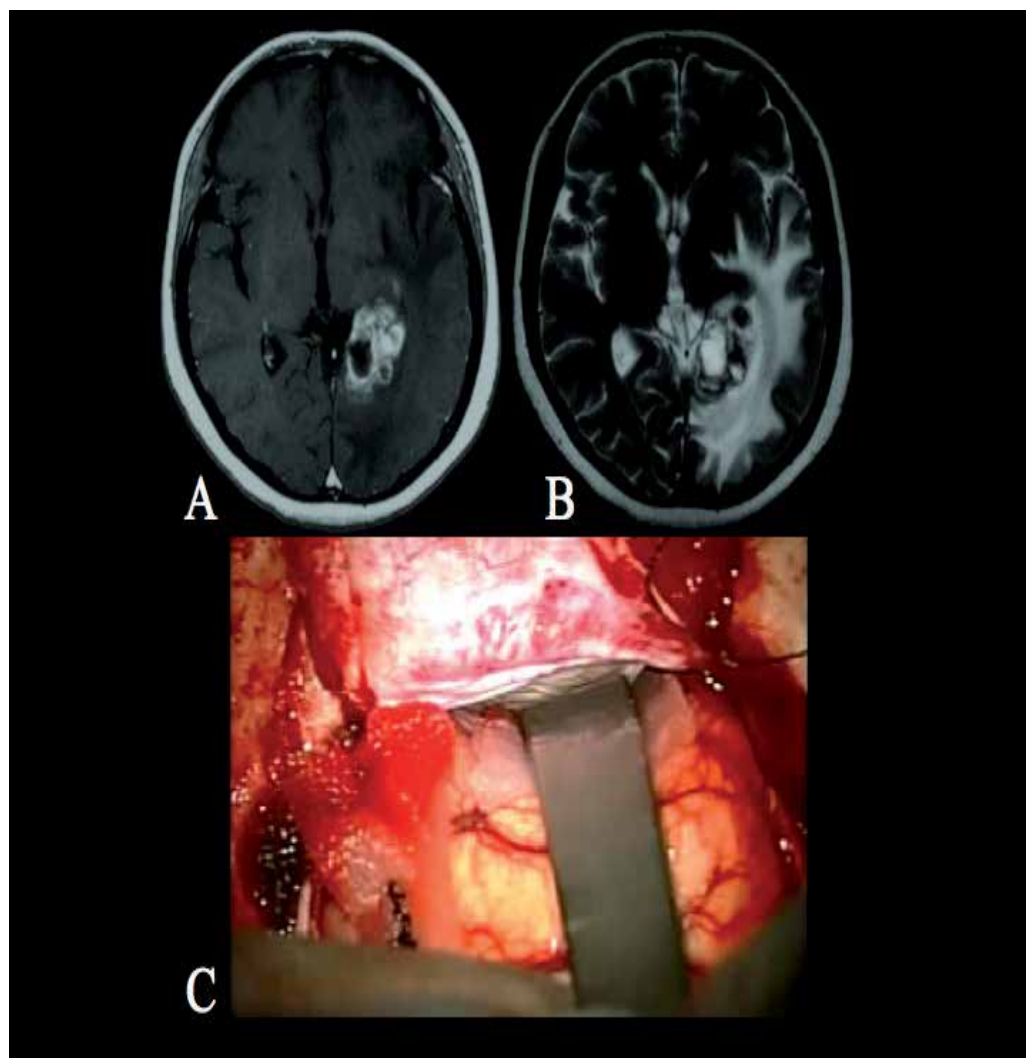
Metastatic trigone tumor of the left trigone (A: T1-weighted image, B: T2-weighted image, and C: intraoperative view of the left occipital lobe)
